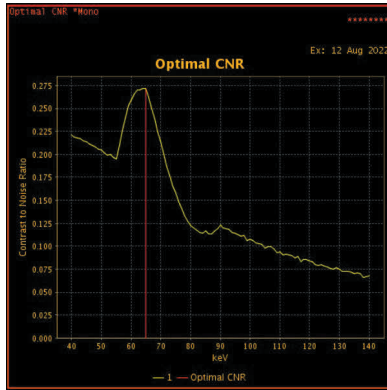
Iodine CNR of virtual monochromatic CT images at energies ranging from 40 keV to 140 keV.
